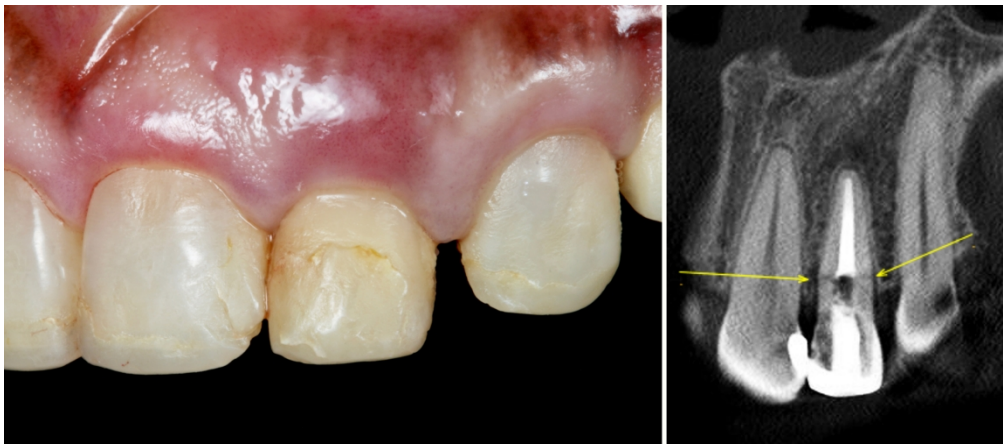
Initial situation. Left: Soft tissue inflammation around the lateral incisor. Right: CBCT image showing the horizontal fracture at the infra-bone level.
